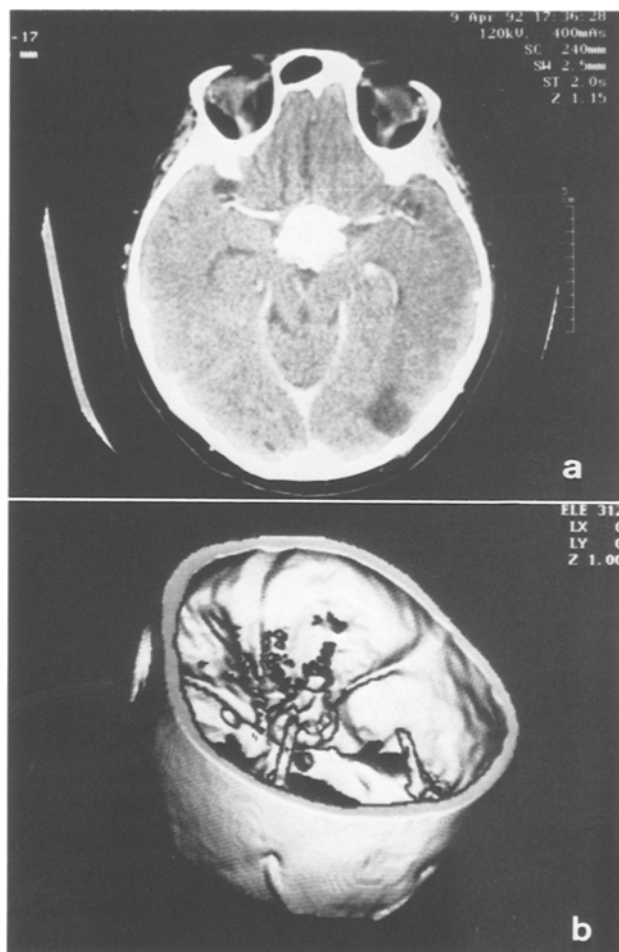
(a) CT-scan demonstrates calcified tumour in the sellar region. (b) The 3 D CT reconstruction of the calcified lesion
